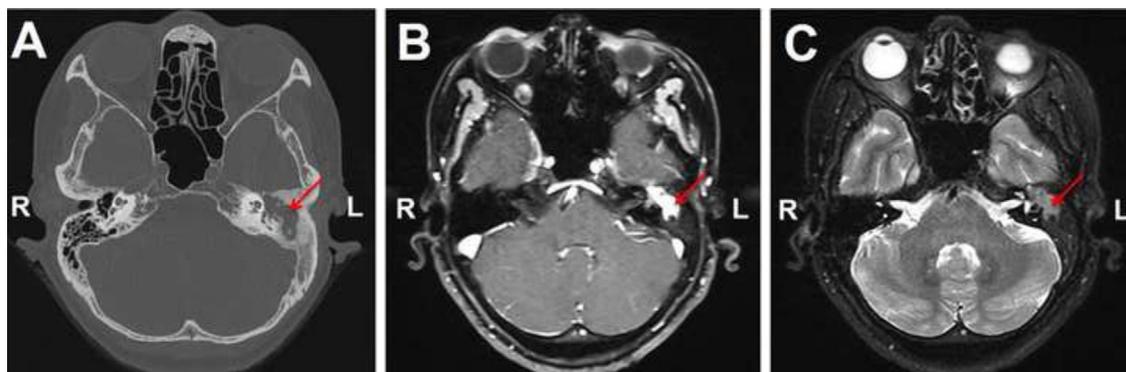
A: CT with bone windows; B: contrasted T1-weighted MRI; C: T2-weighted MRI of the temporal bone preoperatively. The red arrows indicate the lesion site.
